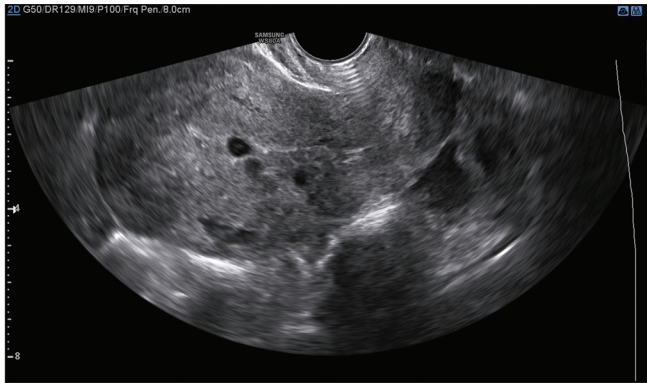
Grayscale bidimensional ultrasound image showing longitudinal view of uterine body with anechoic area suspect for incomplete miscarriage
